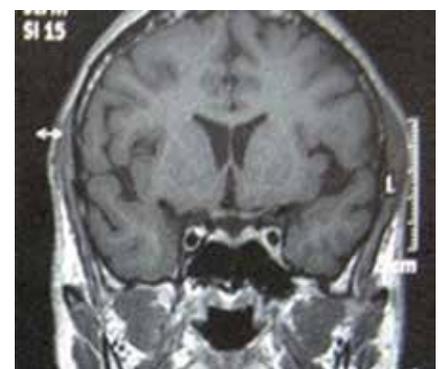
Repeat MRI 6 months post treatment shows normal calibre of internal carotid artery within cavernous sinus.
